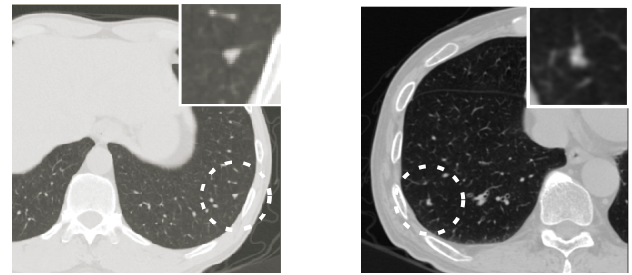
shows the examples of inflammatory nodules and other type (cancer). Nodules exist in dotted circles. Enlargements of nodules are shown at upper right areas in these figures. In the case of a inflammatory nodule (Figure 2(a)), because the tissue of the nodule stay in a secondary pulmonary lobule near the pleura and the pulmonary veins exist along interlobular septums, the above medical findings can be observed. For instance, it is confirmed that a inflammatory nodule(Figure 2(a)) have an almost uniform CT values inside of the nodule and linear boundaries in comparison with an other type (Figure 2(b)).
